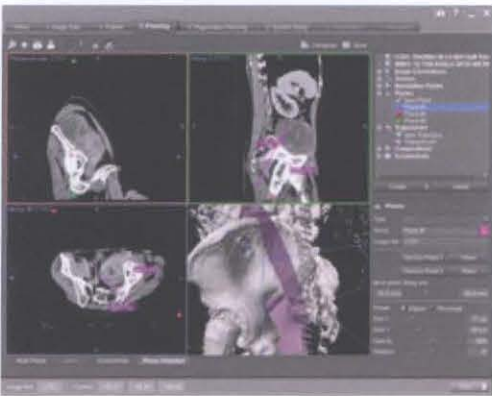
CT image used for Navigation of Pelvic Anatomy (courtesy of Stryker South Pacific)
